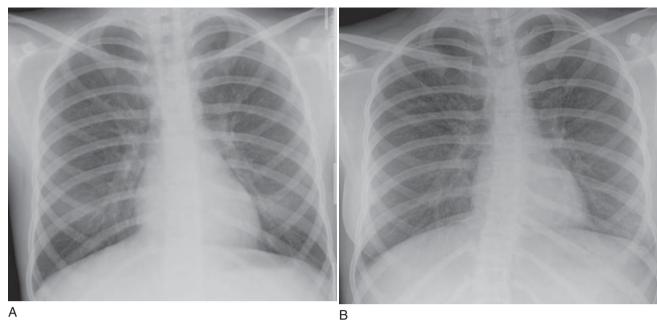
Benefit of digital imaging. Radiographs in a patient taken with film-screen (A), computed radiography (B), and digital radiography (C). Because of the improved dynamic range of digital imaging, there is improved visualization of the mediastinum, vertebrae, and retrocardiac lung without loss of detail of the remaining parenchyma.
